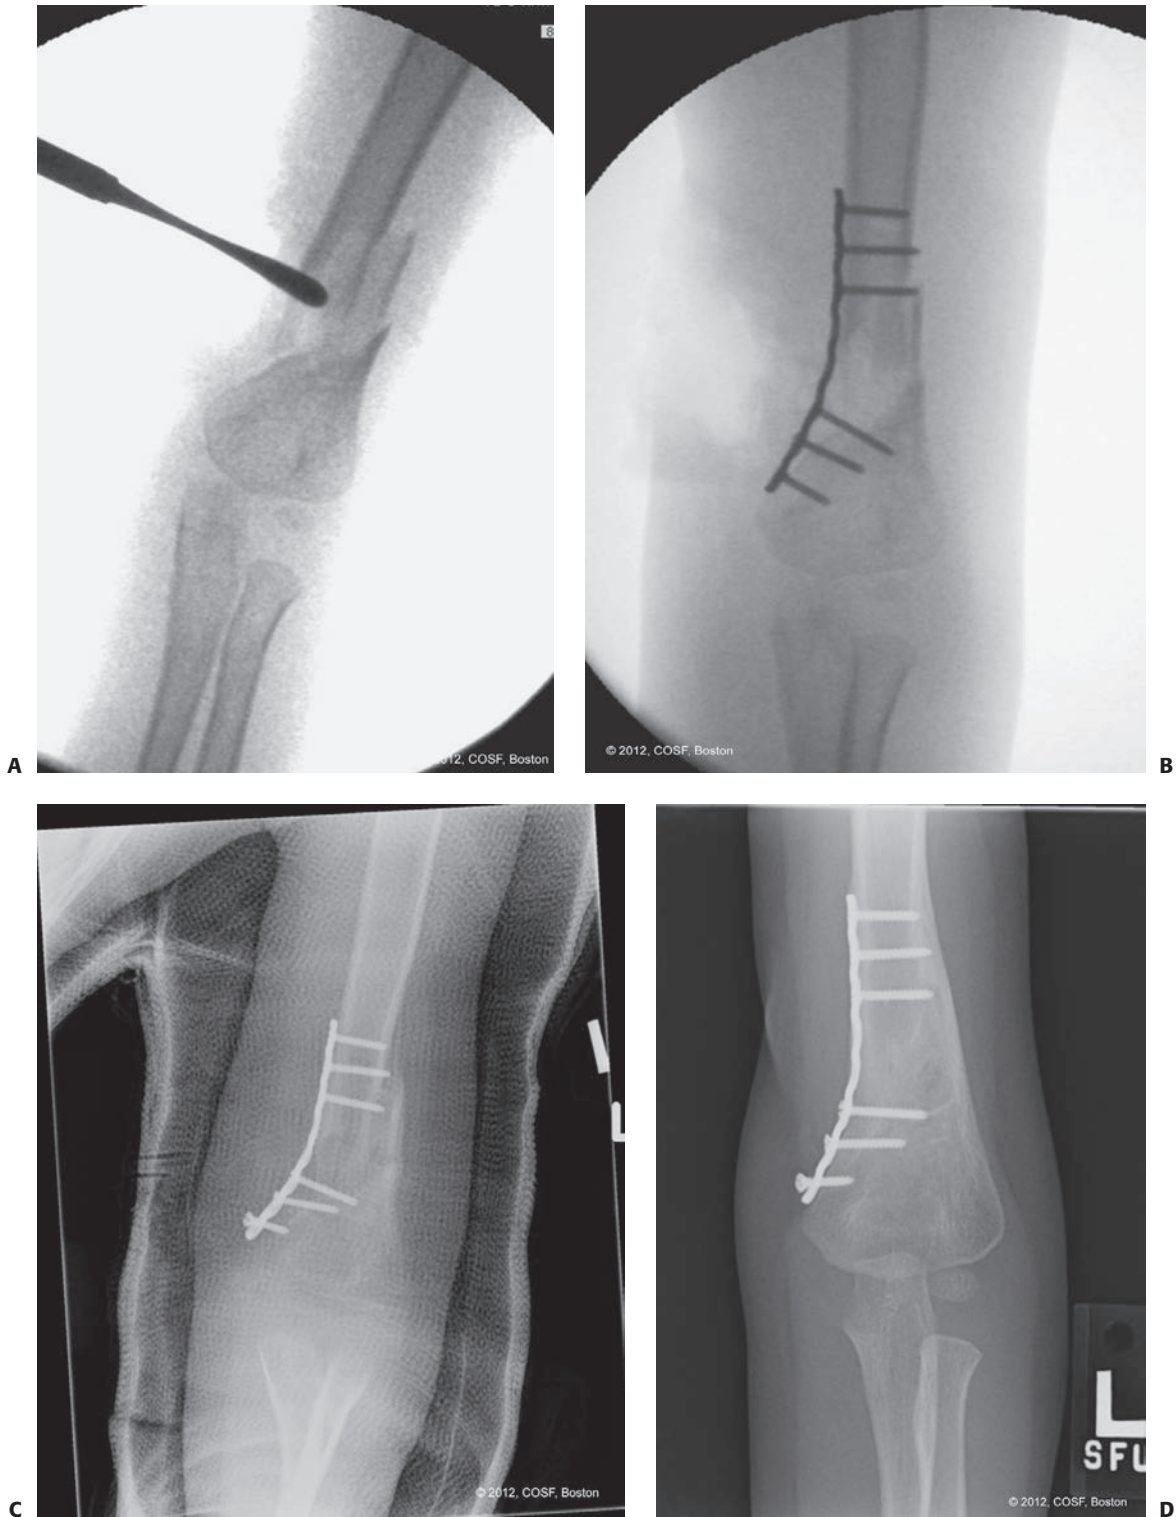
A: Intraoperative image depicting a comminuted, open distal humerus fracture in a 3-year-old male after a motorcycle injury. B: Intraoperative image after lateral column plate fixation, sparing the distal humeral physes. C: Given single column fixation, some loss of fixation is seen. Internal fixation was supplemented with spica cast immobilization. D: Final radiographs demonstrate appropriate bony healing and alignment.
